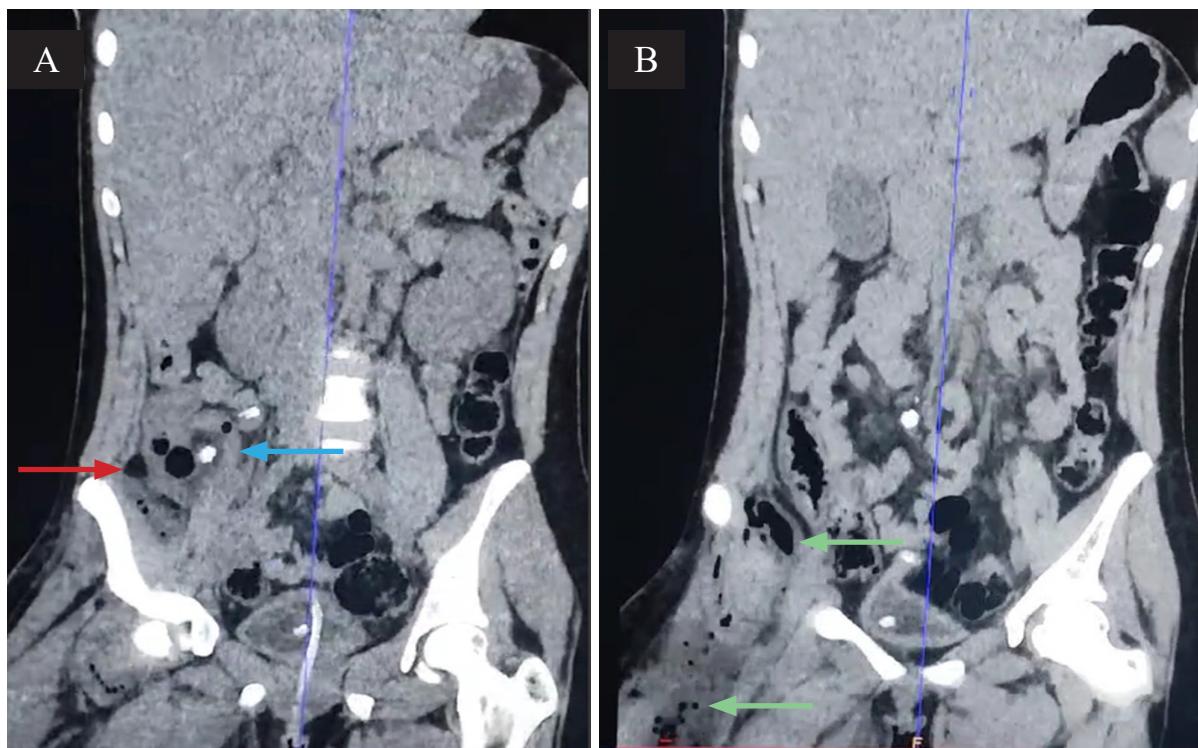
Computed tomography scan of the abdomen; 2A – The blue arrow demonstrates an appendix with a faecalith, and red arrow indicates retroperitoneal air locules; 2B – The green arrows demonstrate free air tracking from the right iliac fossa into the anterior thigh
